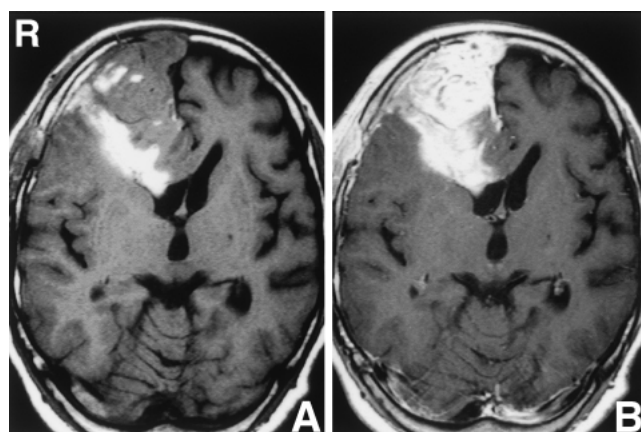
Case 1. T₁-weighted magnetic resonance images after the first operation (A) and with contrast medium (B) demonstrating a well-enhanced mass lesion extending into the superior sagittal sinus. Small intratumoral hemorrhage and bone defect of the internal table of the calvaria are seen.
